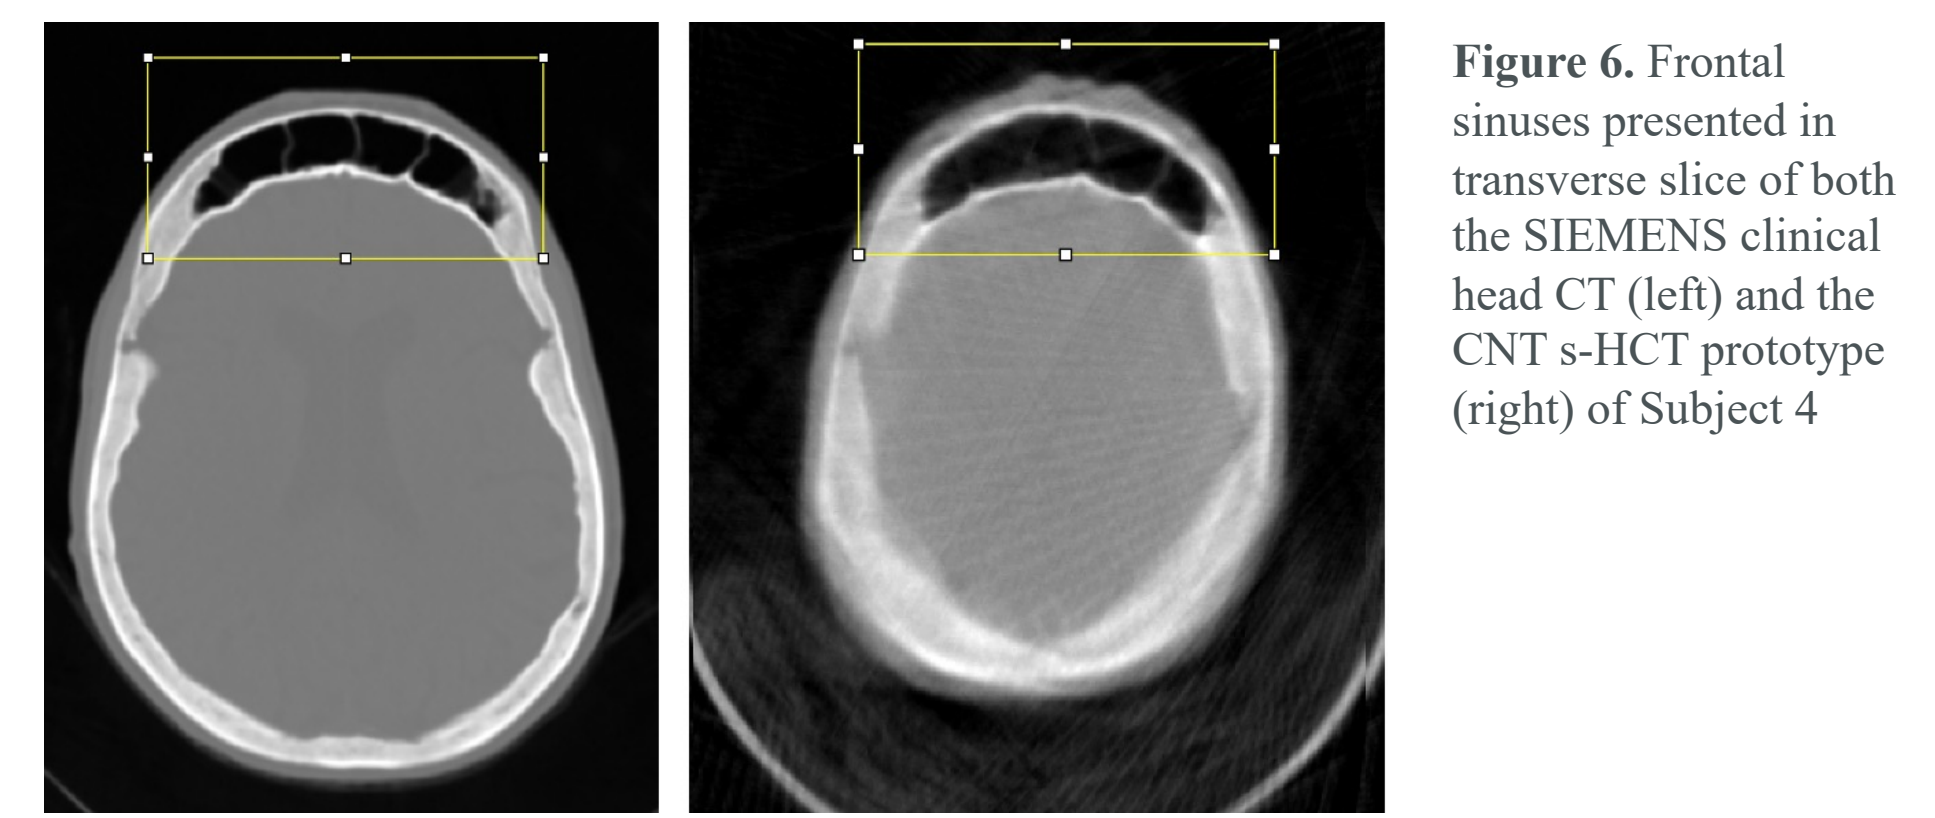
Frontal sinuses presented in transverse slice of both the SIEMENS clinical head CT (left) and the CNT s-HCT prototype (right) of Subject 4
